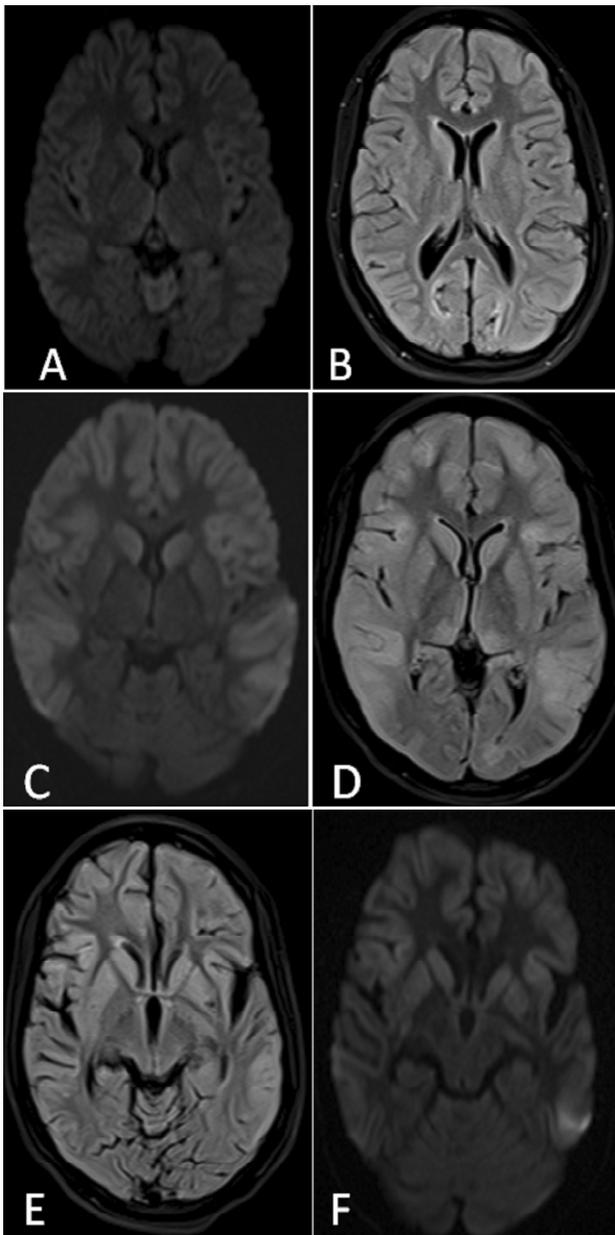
An 18-year-old female presented with a status epilepticus. The MRI scan demonstrates mild diffusion restriction along the cortical and sub cortical regions of bilateral cerebral hemispheres on diffusion weighted image (A) and subtle hyperintense signal in periventricular white matter in peritrigonal areas in corresponding FLAIR image (B). Follow-up scan after ten days for assessment of progression in disease and treatment effect. The MRI reveal bilateral symmetrical areas of altered signal intensities seen involving bilateral basal ganglia, inferomedial aspects of bilateral thalami, bilateral frontal, temporal and parietal lobes. There is mild swelling of underlying cortical grey and subcortical white matter that appear hyperintense on axial FLAIR image (C) and show restriction on the diffusion-weighted image (D). Follow-up scan after twenty days for progression of disease and treatment effect where MRI demonstrates bilateral symmetrical abnormal high signals on axial FLAIR image (E) involving caudate nucleus, putamina and cortical gyri showing restriction on the diffusion-weighted image (F). These MRI findings are showings further deterioration in the patient condition.
